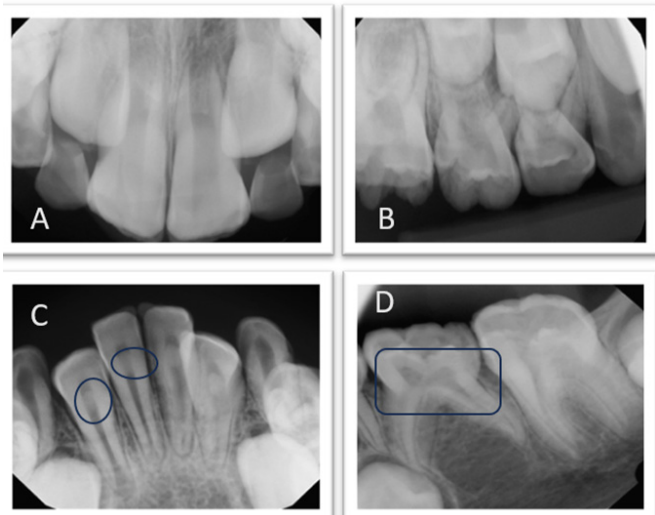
Radiographic findings: A and B: Maxillary anterior and posterior teeth showing dental crowding; C: Mandibular anterior teeth showing pulp stones; D: Posterior teeth with slightly enlarged pulp chamber and short roots.
